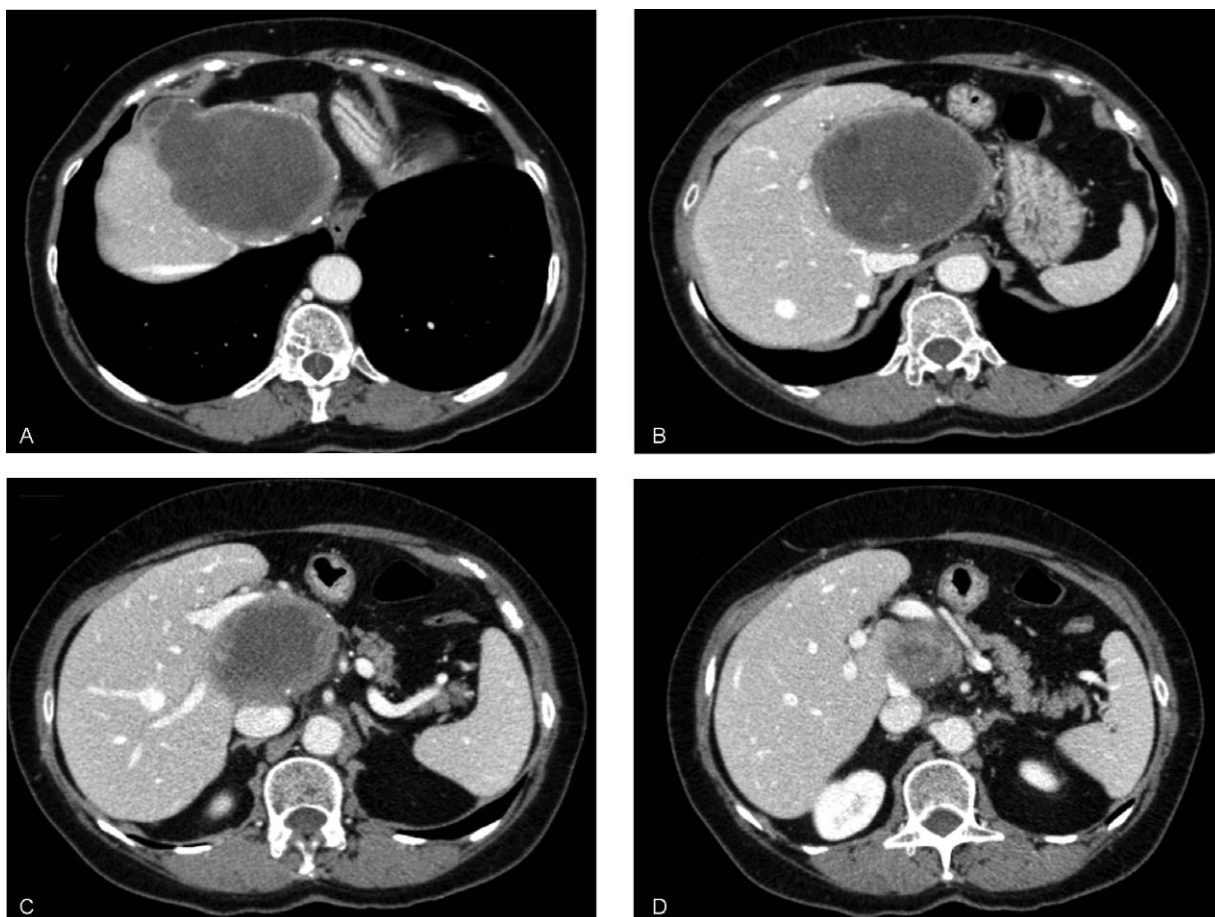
CT scan showing a complex hydatid cyst of the liver in 60-year old woman, presenting with symptoms of recurrent cholangitis due to cysto-biliary communication (A). The cyst caused compression of the inferior vena cava, left and middle hepatic veins (B and C). The inferior aspect of the cyst was in contact with the hepatic hilum, resulting in compression of the portal vein (D). To note, the cyst also caused atrophy of the left lobe. The patient underwent a sub-total pericystectomy, followed by hilar biliary duct-jejunostomy for recurrent episodes of cholangitis after 6 months. After 1 year from the first surgery the patient deceased for sepsis caused by carbapenem-resistant *K. pneumoniae*.
